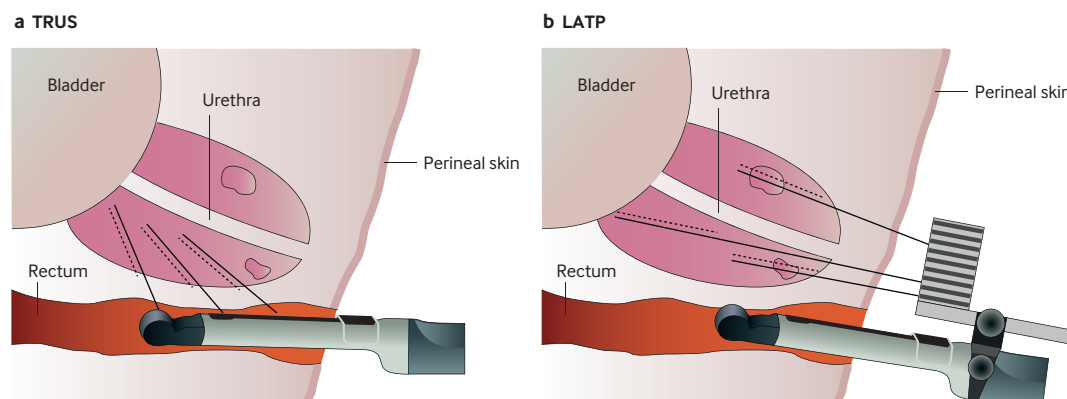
(A) Transrectal ultrasound (TRUS) guided prostate biopsy and (B) Local anaesthetic transperineal (LAMP) prostate biopsy differ by route of entry, being either transrectal (TRUS) or transperineal (LAMP). Both involve a transrectal ultrasound probe and insertion of core biopsy needles into the prostate for diagnosis of prostate cancer
